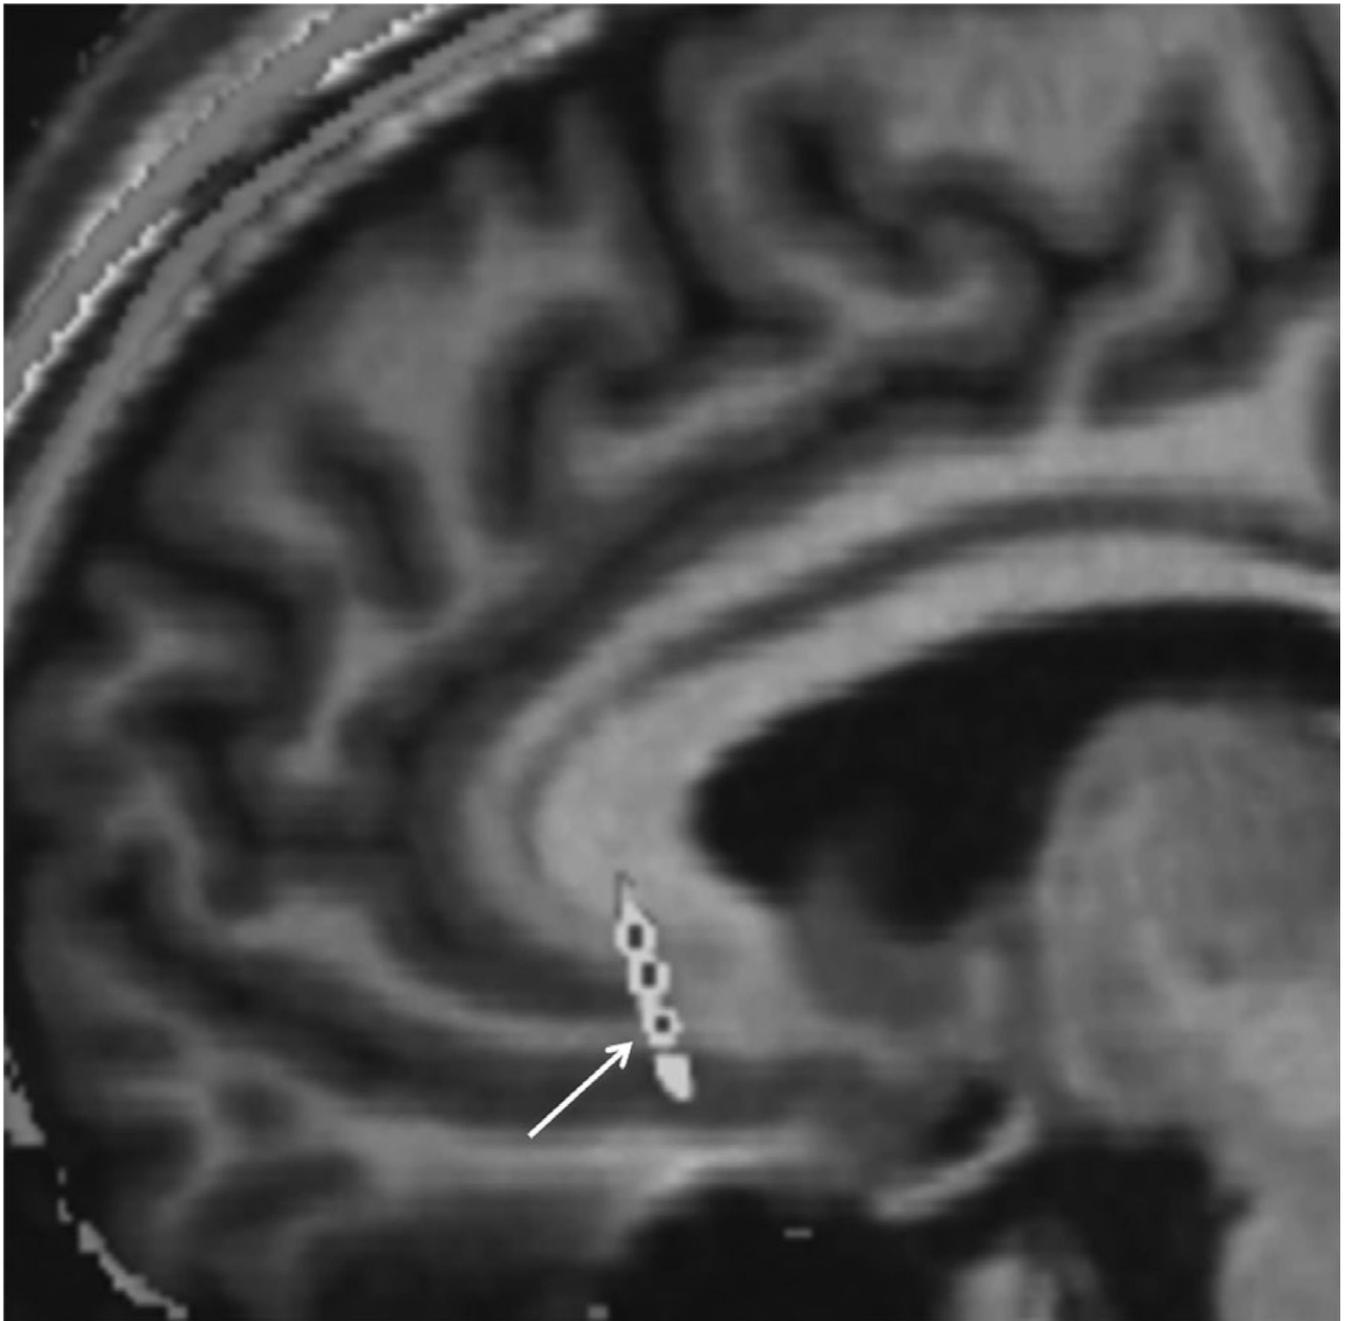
Subcallosal cingulate white matter deep brain stimulation target. Sagittal view of a representative single patient's preoperative MRI scan coregistered with the post-operative high-resolution computed tomography scan used to visualize electrode lead placement. Arrow indicates the active contact in this patient. Stimulation was delivered at 130 Hz, with a 91 μ s pulse width, and 6–8 mA current.
